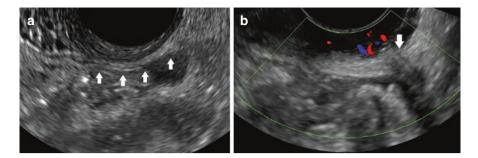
(a) Expected appearance of the uterosacral ligament (USL) on ultrasound. The white arrows are positioned on the peritoneal aspect of the left USL. (b) Aspect of endometriosis within the left USL: hypoechoic image, with Doppler score 1, in contrast with the hyperechoic structure of the ligament
